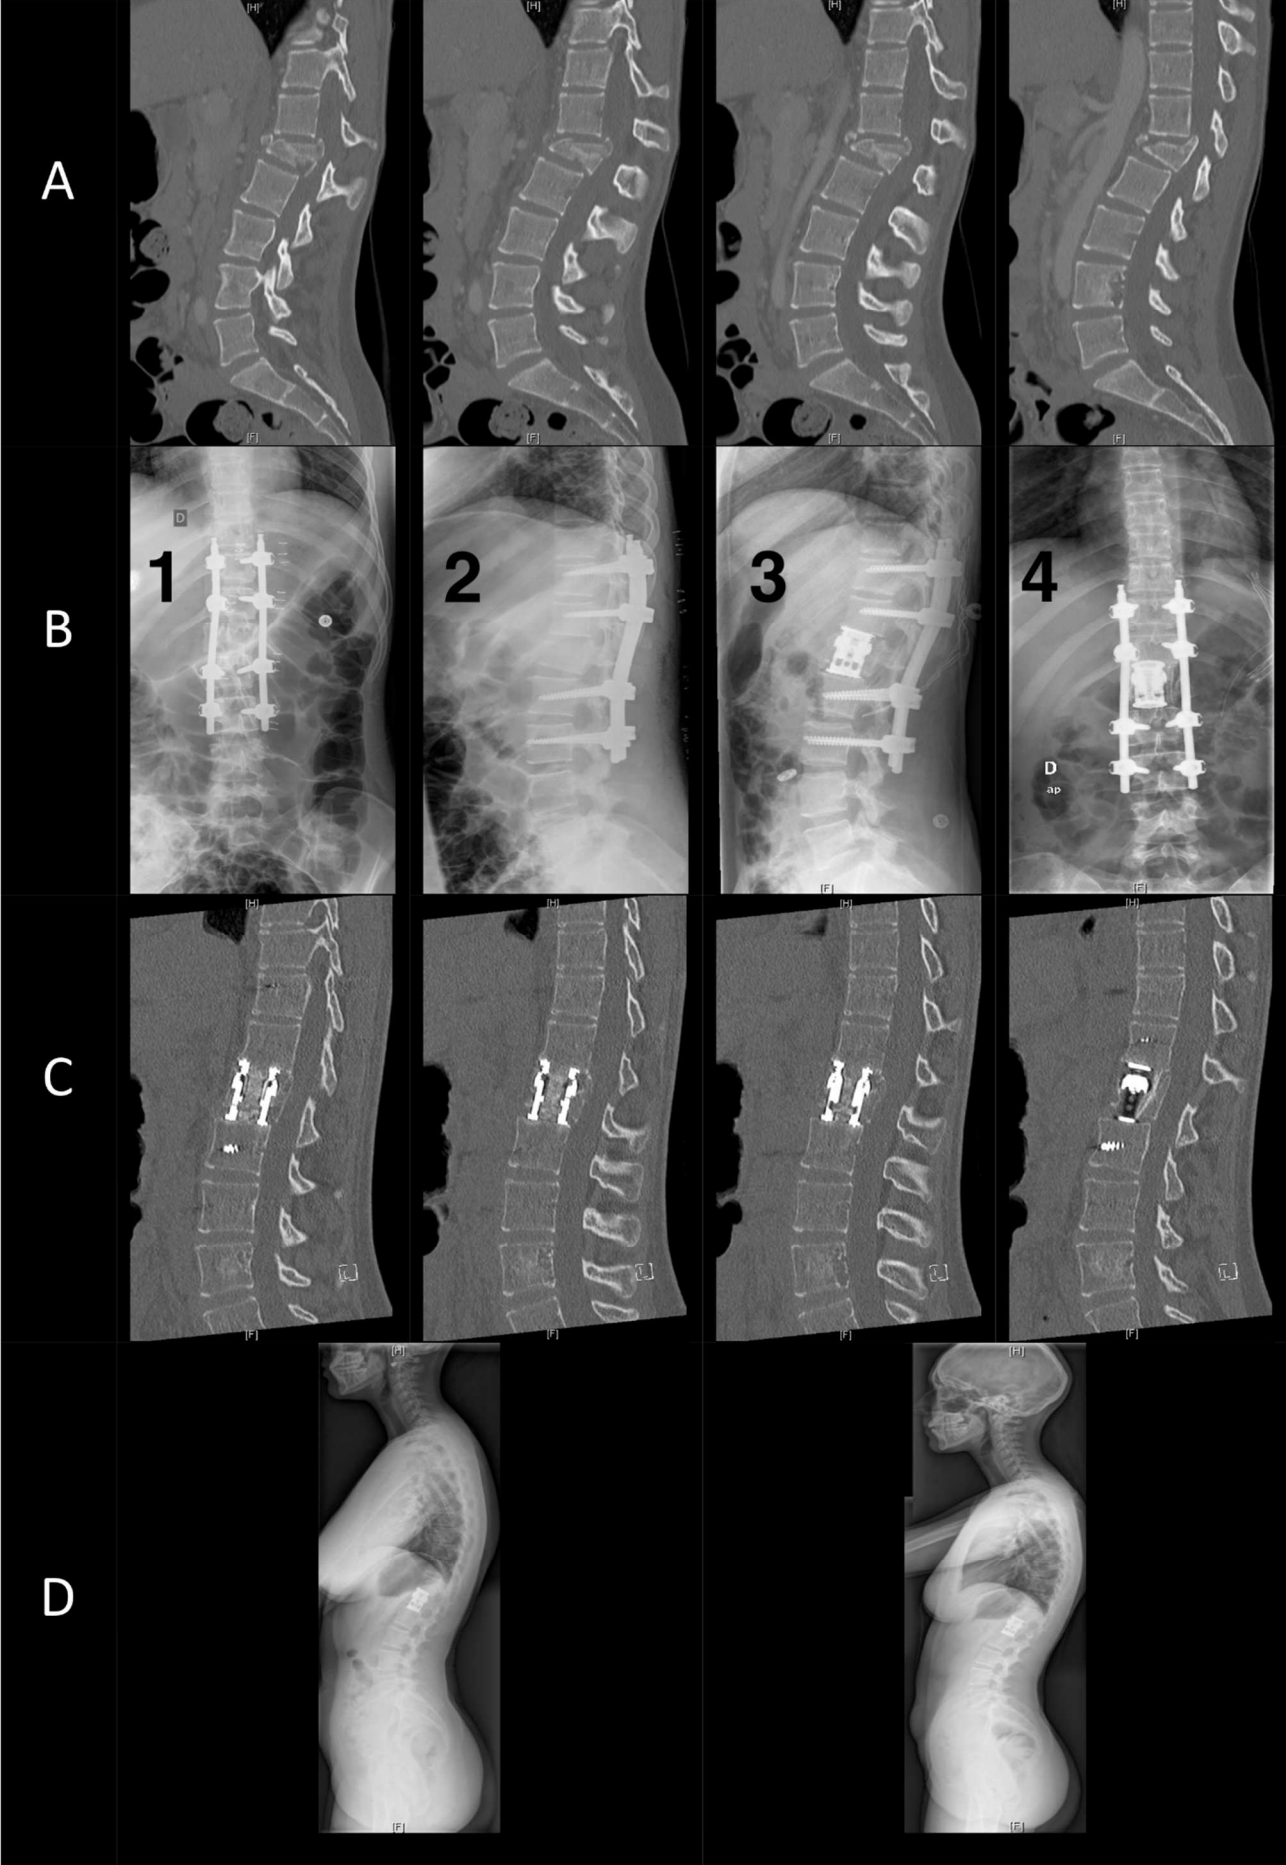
Example of a 3-stage sequential treatment of a post traumatic L1 A4 (AoSpine) fracture in a 25-year-old woman. Images A: sagittal bone CT showing the fracture. Images B: after posterior MIS osteosynthesis (first 2 images) and after previous arthrodesis treatment (last 2 images). C: Sagittal bone scan at 1 year showing absence of pseudarthrosis with complete ossification. D: Sagittal Tele-column after removal of posterior MIS instrumentation after 1 and 2 years showing good stability with a correct sagittal balance without local sagging.
